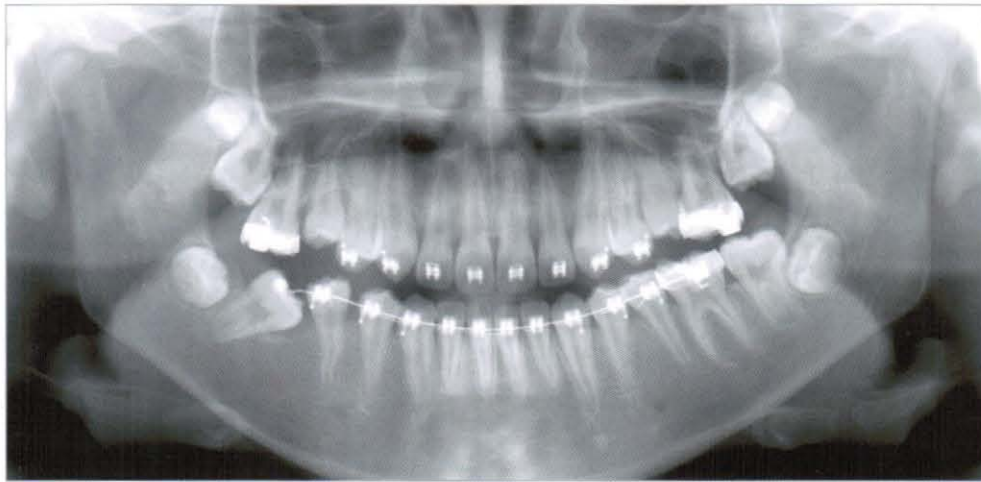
Uprighting of the lower right second molar checked on panoramic radiograph (2004, 12,10)
